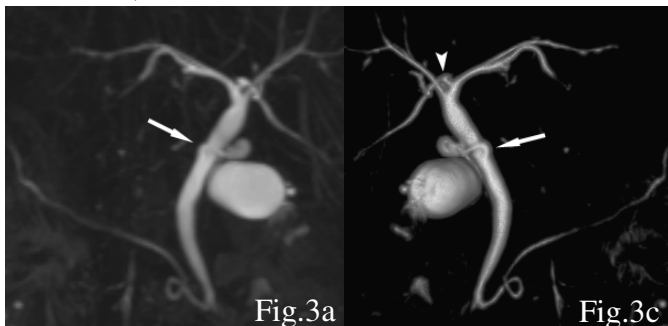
A 53-year-old woman with gallstones; images are from free-breathing navigator-triggered 3D T2-weighted TSE MRCP. (a) This MIP image viewed from the dorsal side appears as if the cystic duct (*arrow*) drains into the left posterior side of the middle extrahepatic bile duct from the dorsal side. (c) This VR image viewed from the ventral side clearly displays the cystic duct (*arrow*) draining into the left anterior side of the middle extrahepatic bile duct from the ventral side. It also clearly displays a biliary branching anomaly in which the right posterior segment hepatic duct (*arrowhead*) drains into the left hepatic duct.
